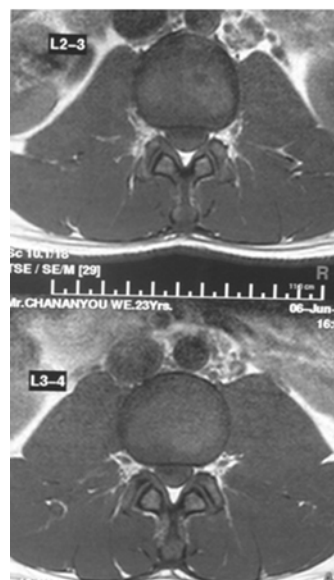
Transverse MRI at the L2/L3 and L3/L4 vertebral levels shows no disc herniation.
